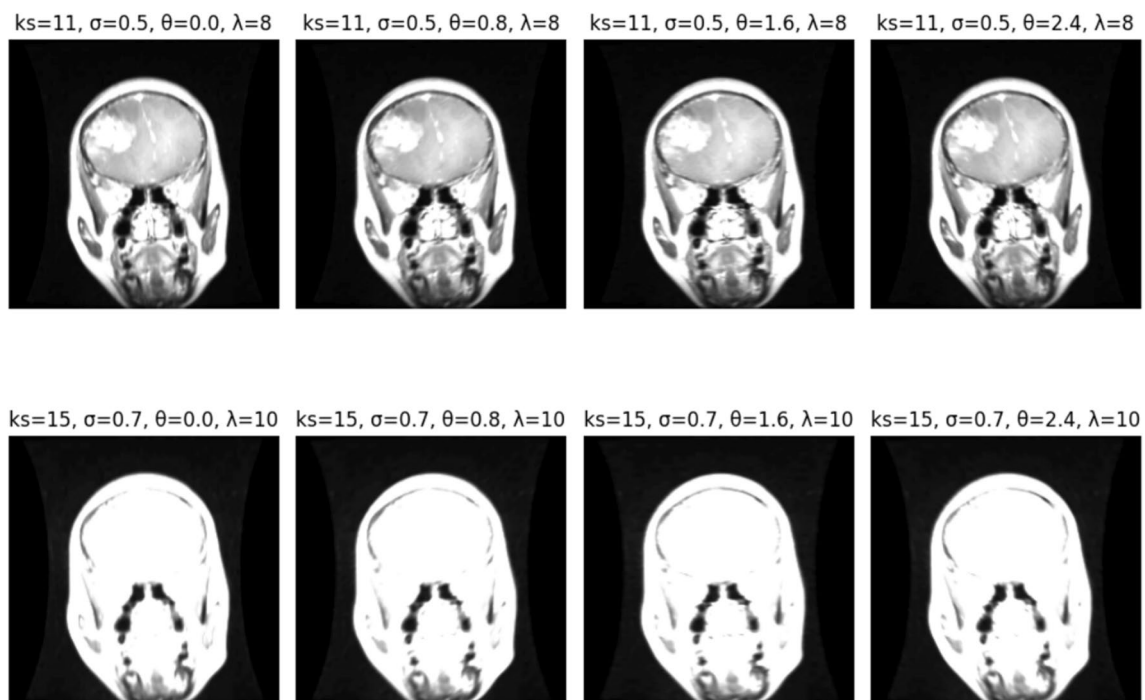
Gabor filter-based representation of an input MRI image, highlighting the textural features extracted through multi-scale and multi-orientation kernels, demonstrating the Enhanced Gabor Layer’s role in capturing tumor-specific patterns
